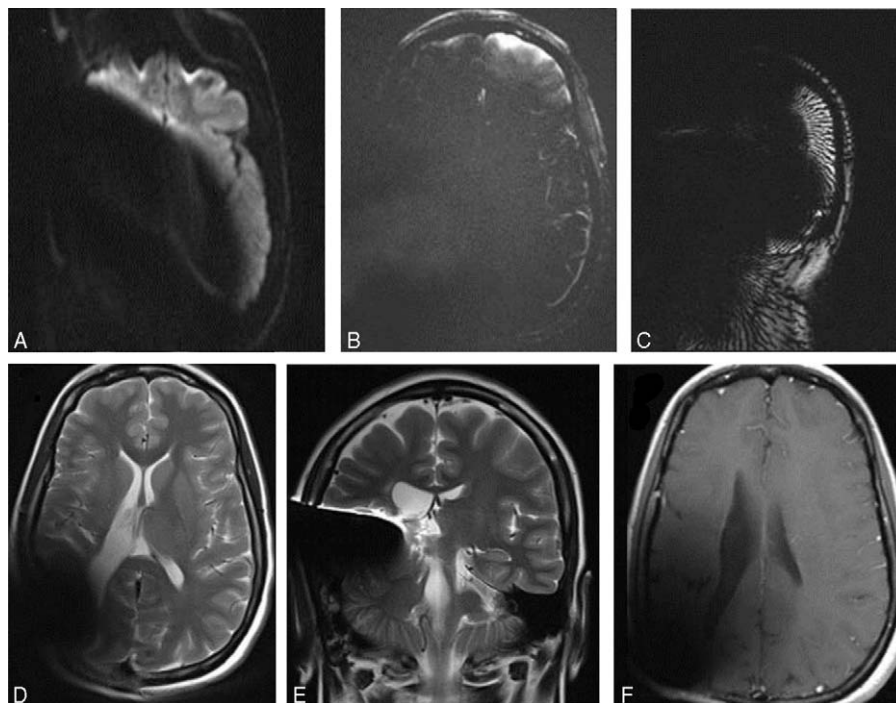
Brain imaging with a CI magnet in situ (implanted right ear). Diffusion-weighted echo-planer images (A), hemorrhage sensitive sequences such as gradient recalled echo (B), and susceptibility weighted imaging (C) are generally non-diagnostic. In comparison, T2-weighted (D and E) and T1-weighted (F) fast spin echo images often are more useful due to more localized artifact.
